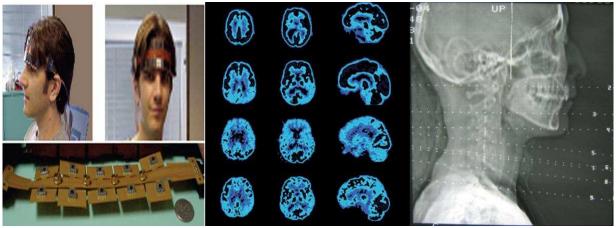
Other, non-electrophysiological measurement techniques (from L to R: NIRS (near-infrared imaging -- fNIR system shown), PET (positron emission tomography), and x-ray technology.
